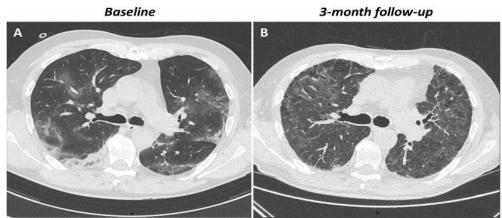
Axial CT scans at baseline show ground-glass opacities and at 3months follow-up traction bronchiectasis and reticular opacities are noticed <sup>(8)</sup>.
